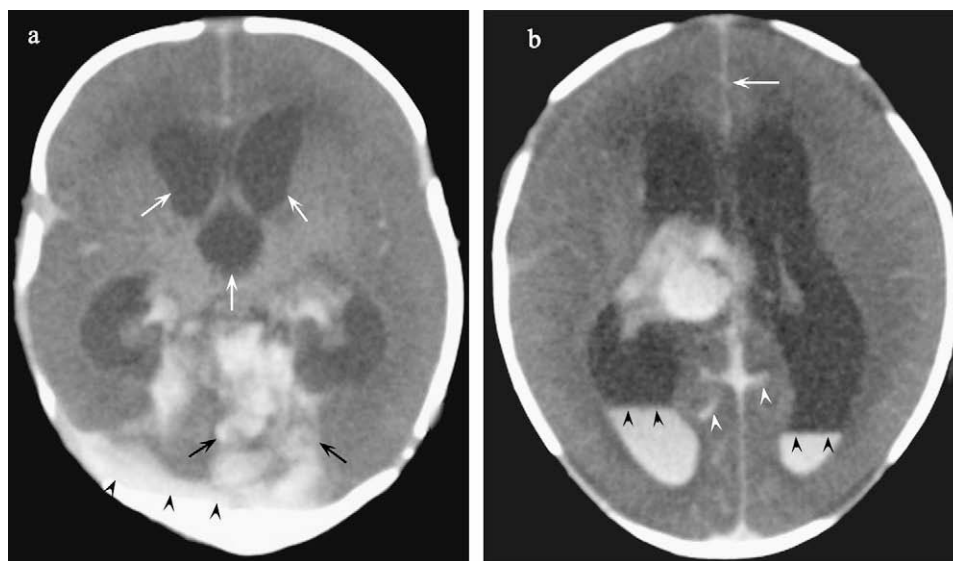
Cranial computed tomography performed within the first 24 hours after birth. All images are of the same term newborn. (a) The presence of three types of supratentorial intracranial hemorrhage (subdural hemorrhage, black arrow heads; intraparenchymal hemorrhage, black arrows; and ventricular enlargement, white arrows) points to a severe intracranial hemorrhage. (b) Subarachnoid hemorrhage of sulci (white arrow heads) or interhemispheric subarachnoid hemorrhage (white arrow), and intraventricular hemorrhage imaged as hyperattenuating fluid layering in dependent portions of the lateral ventricles (black arrow heads).
